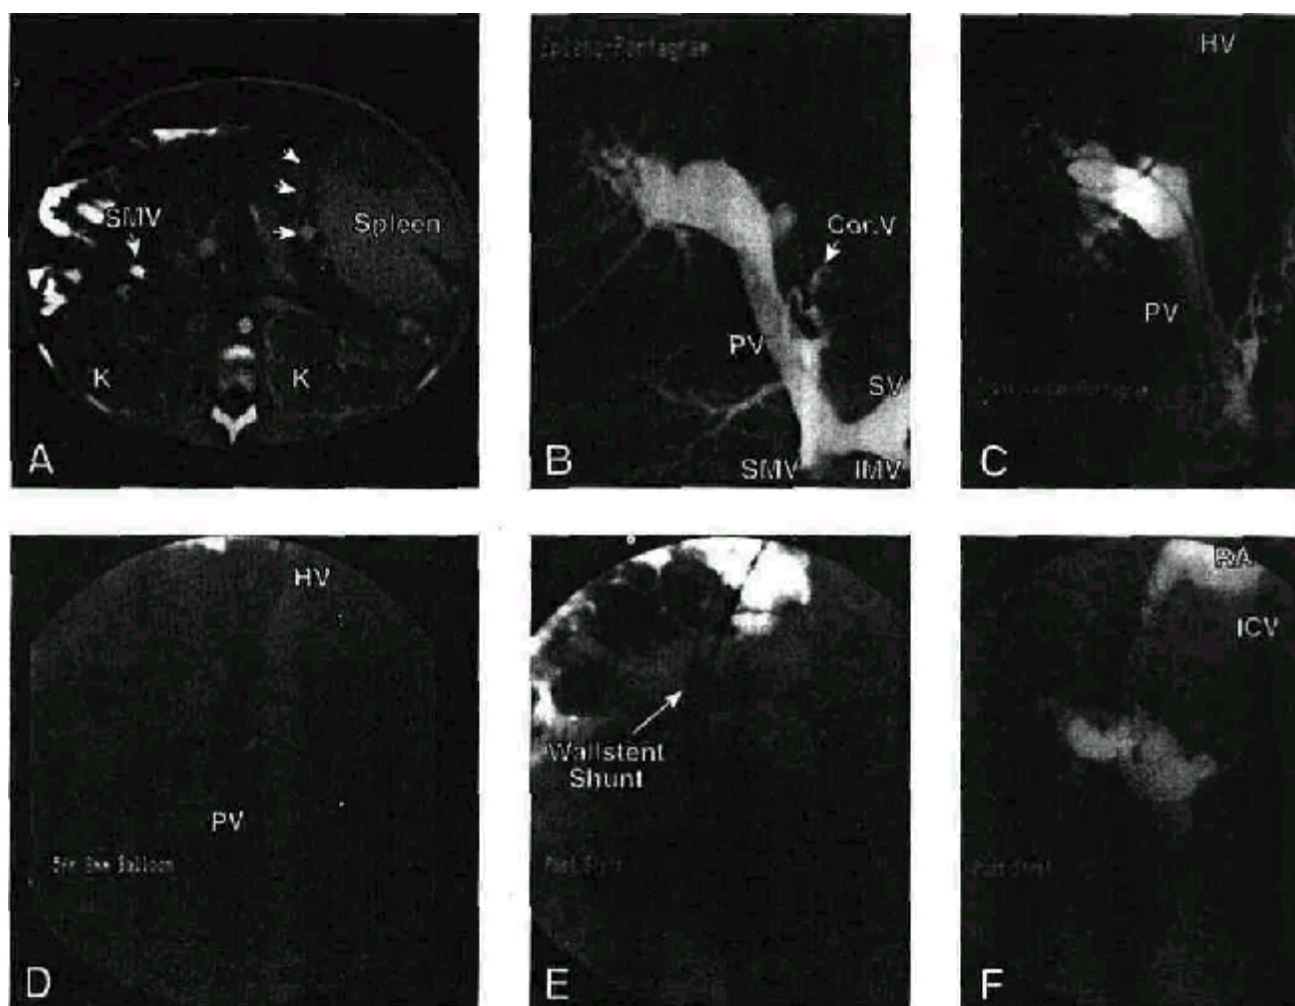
The patient is a 7-year-old girl with portal hypertension secondary to congenital hepatic fibrosis. A, Computed tomographic scan shows a massively enlarged spleen with serpiginous variceal collaterals apparent in the splenic hilum (*arrows*). The large kidneys with characteristic low attenuation, signal are also seen. The large superior mesenteric vein (SMV) is patent. Images obtained closer to the head demonstrate a patent portal vein. B, Splenoportogram shows the extrahepatic venous anatomy. The splenic vein (SV) is confluent with the superior mesenteric vein (SMV). The portal vein (PV) is patent, and flow is hepatopetal. The inferior mesenteric vein (IMV) is seen, and the coronary vein (COR V) is shown coursing toward the head. C, Through a transjugular approach, a 10-French catheter has been placed in the hepatic vein (HV). The portal vein is identified, and a 5-French catheter is inserted into its lumen. D, A balloon has been placed and inflated in the liver between the hepatic and portal veins. The inflated balloon establishes and dilates the connection between the systemic and portal circulations. E, The tract is secured by placement of an 8-mm Wallstent
